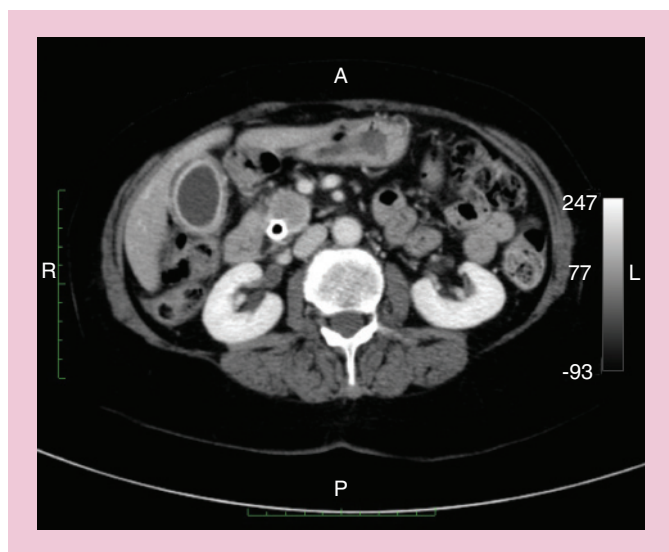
Multidetector CT-scan image (portal venous phase) of a 77-year-old female with a 2.5-cm pancreatic cancer tumor in the uncinate process. Note the removable metal stent *in situ* to relieve biliary obstruction.
